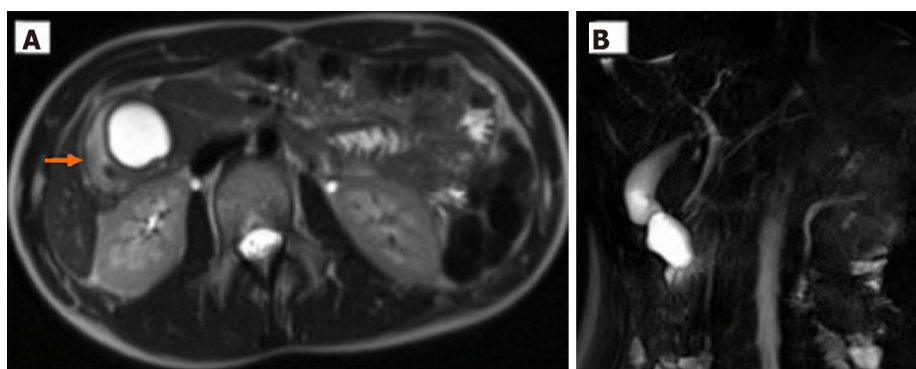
Magnetic resonance imaging of case 2. A: Round homogeneously hyperintense lesion at the level of uncinate process of the pancreas determined a major compression on the second portion of duodenum (arrow); B: At cholangiographic reconstruction, the intra- and extrahepatic biliary tree and pancreatic ductal system were normal.
